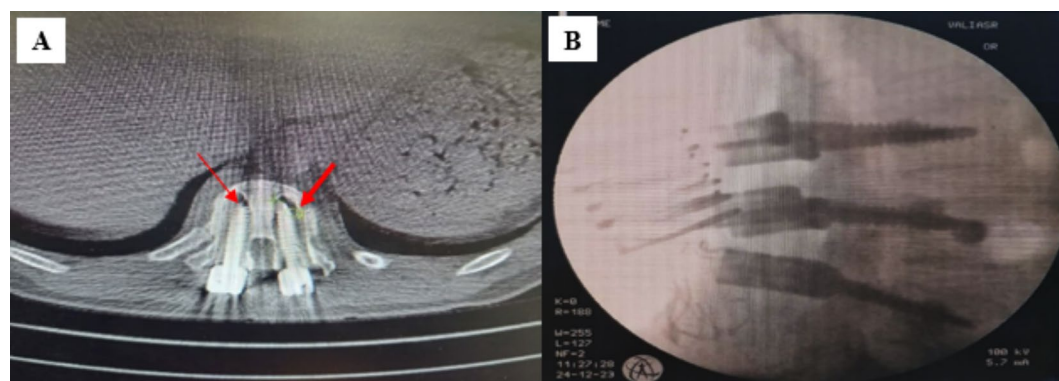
(A) CT scan axial plane. A no signal zone surrounding whole body of screw indicates the loosening of the screw. (B) The Fluoroscopic control during cement application.
